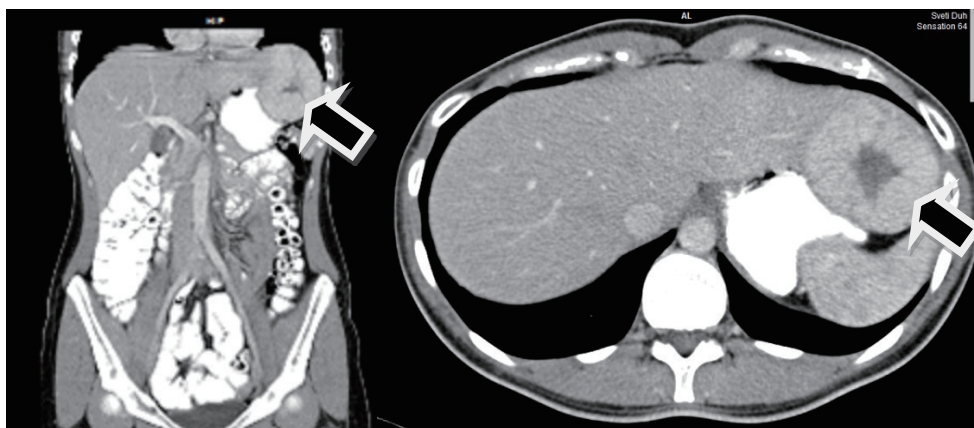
Magnetic resonance imaging (MRI) record of the operated patient with focal nodular hyperplasia (FNH). The tumor located in segments II and III of the liver, shown with black arrows.
